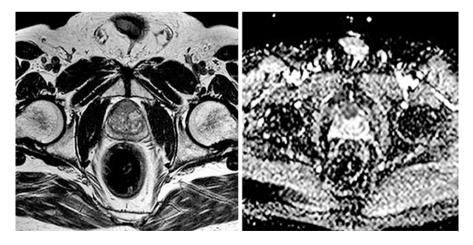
PI-RAD five anterior prostate cancer on MRI. T2 (*left*) and diffusion (*right*) weighted images
